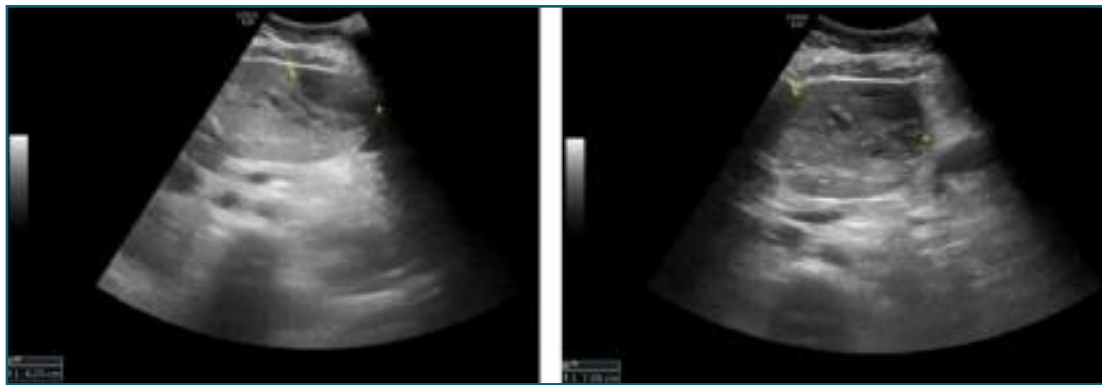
Abdominal ultrasound revealing an heterogenous area in left hepatic lobe, with an anechogenic subcapsular area with 6 cm of major diameter suggesting a subcapsular hematoma (on the left) and an area of heterogeneous density with 8 cm of major diameter suggesting an intrahepatic hematoma (on the right).
